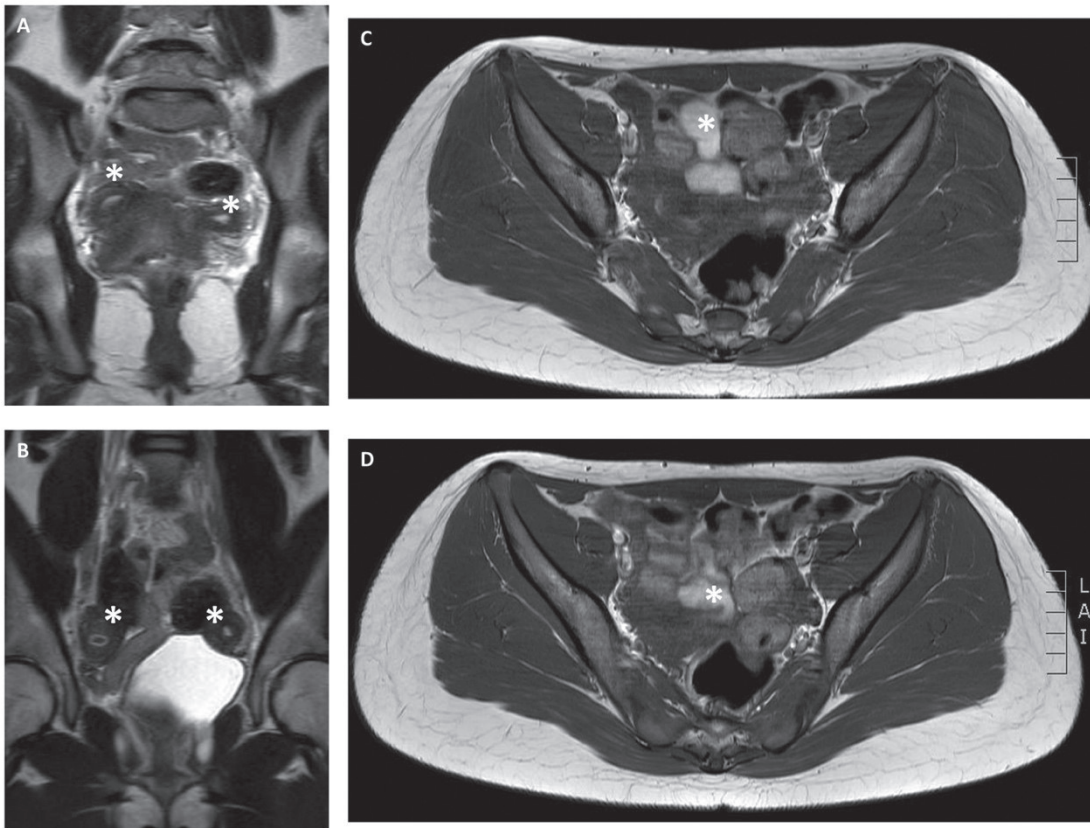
Post-surgery Magnetic Resonance Images. (A), (B) Coronal T2W images showing duplication of the endometrial cavities, both cavities are normal (asterisks). (C), (D) Axial T2W images showing small amount of haemorrhagic material in the right adnexa.
